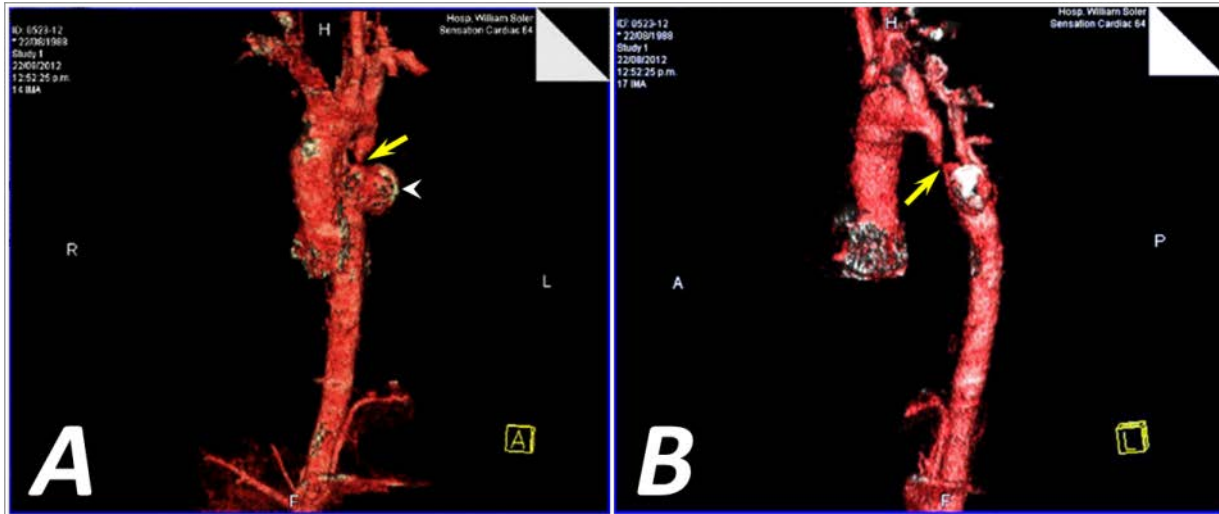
CT angiography views of the aorta (VRT reconstruction) showing CoA with small hypoplastic segment before coarcted area, ending in an image with “pencil point” (arrows), followed by a calcified saccular aneurysm, post-coarctation (arrow). Anteroposterior view (A) and left anterior oblique view (B).
